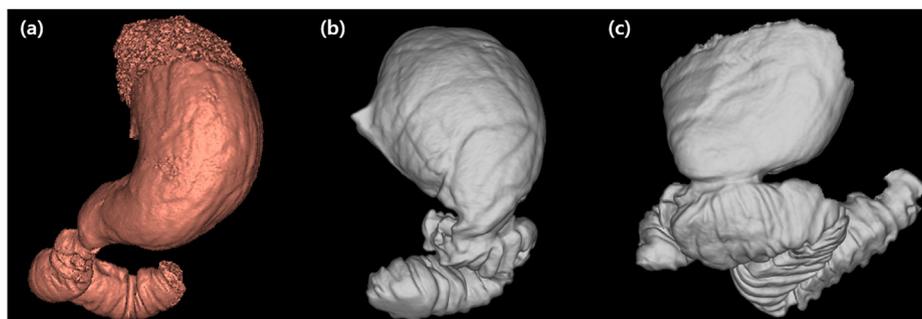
Computed Tomography (CT) gastrography images 3D CT reconstruction images of patients who underwent Billroth-1 anastomosis (a), Billroth-2 anastomosis (b), Roux-en-Y gastrojejunostomy (c).
